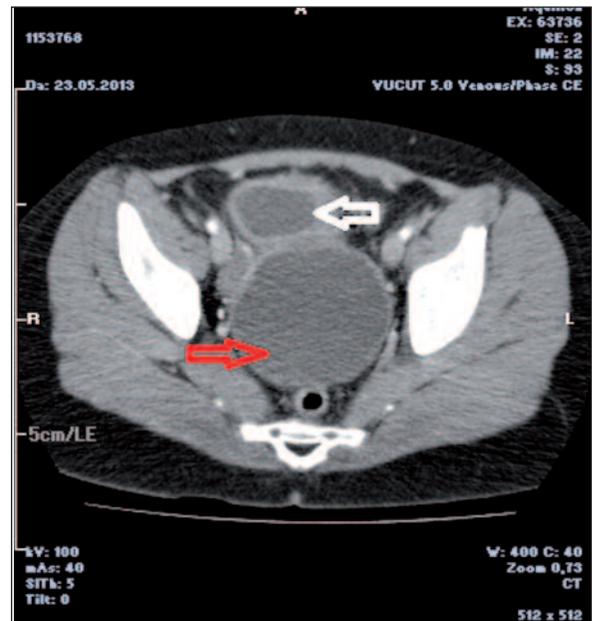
Abdominal computed tomography showing mass (red arrow) and contracted urinary bladder (white arrow).
